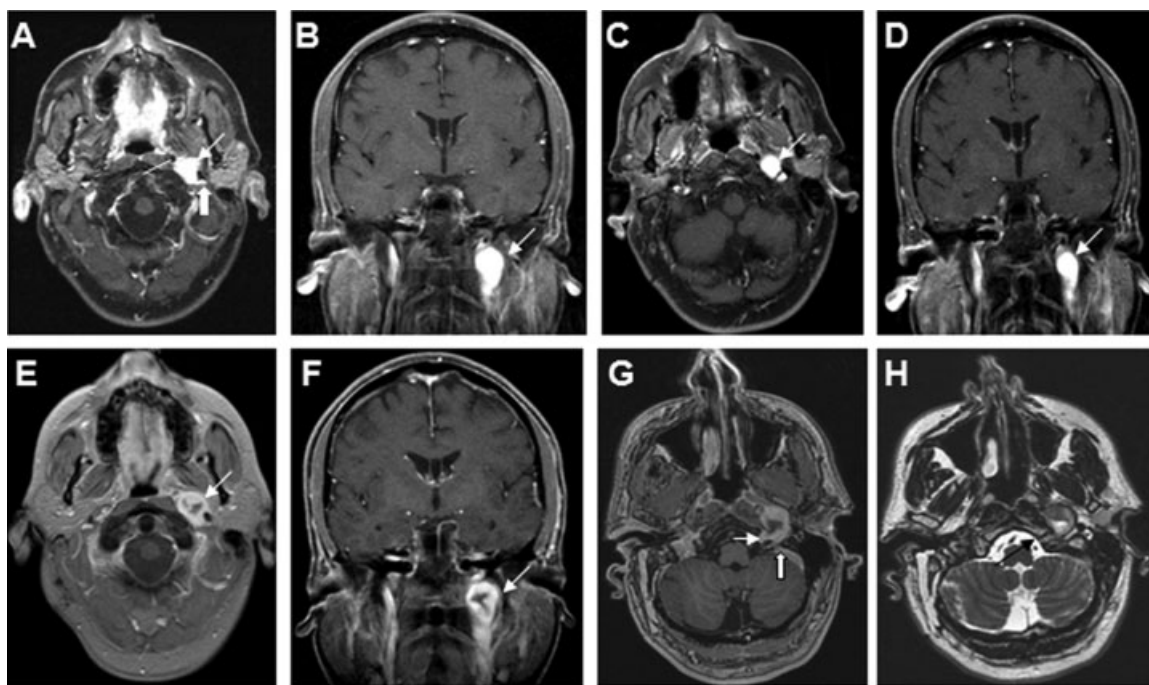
Magnetic resonance imaging scans of the patient, 4 months (2004) after CyberKnife treatment. (A) T1-weighted postcontrast axial view showing a left cervical/skull base lesion (thin arrow) located between the external carotid artery (line) and the internal carotid artery (thick arrow). (B) T1-weighted postcontrast coronal view showing the tumor (arrow) 5.5 years (2009) after CyberKnife treatment. (C) T1-weighted postcontrast axial view showing the lesion (arrow) with a slight decrease in size. (D) T1-weighted postcontrast coronal view showing the lesion 8.5 years (2012) after CyberKnife treatment. (E) T1-weighted postcontrast axial view showing the lesion (arrow) with increased size and hypointensity in the center, consistent with necrosis. (F) T1-weighted postcontrast coronal view showing the lesion (arrow). (G) Fine-cut T1-weighted postcontrast axial view showing the lesion with a tail extending through the hypoglossal canal (thin arrow) and abutting the jugular foramen (thick arrow). (H) Fine-cut T2-weighted axial view again showing the lesion with a tail extending through the hypoglossal canal (arrow).
